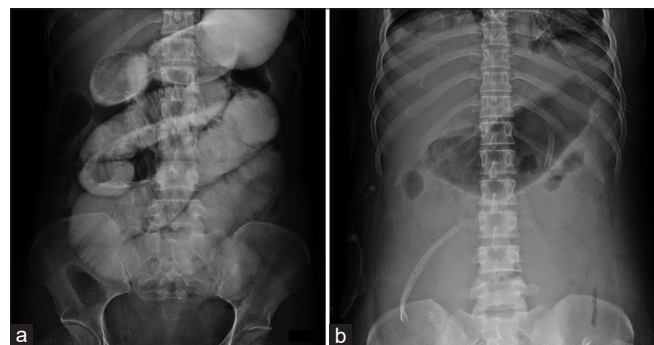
Contrast small bowel series before the first operation showed distended bowel loops (a). After the second operation, a physical examination revealed no bowel movements, and an abdominal roentgenogram showed no bowel gas (b)
